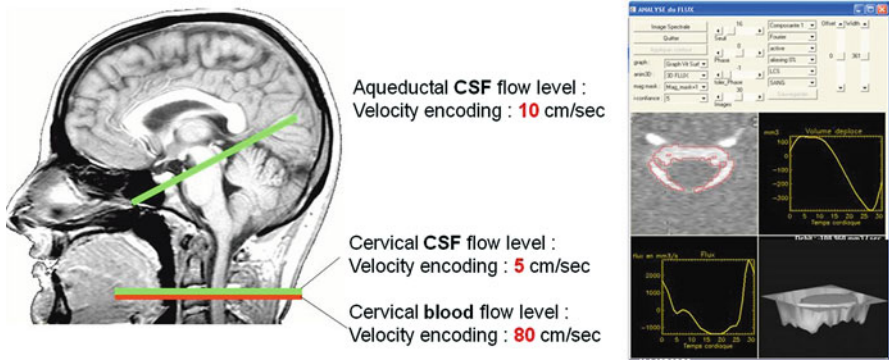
PC-MRI acquisition planes and example of cervical CSF segmentation
